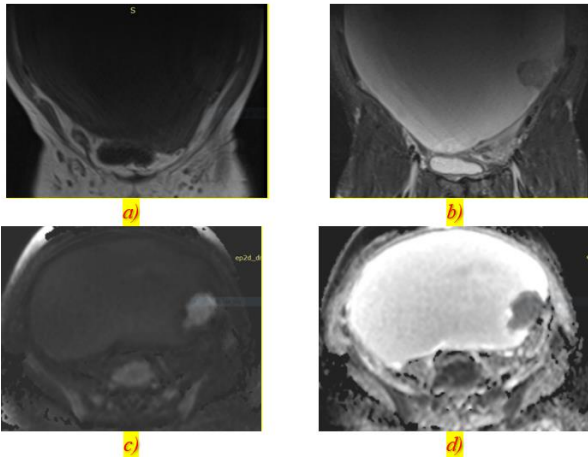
a) Coronal T1 WI;b) Coronal T2WI;c) DWI;d) ADC
